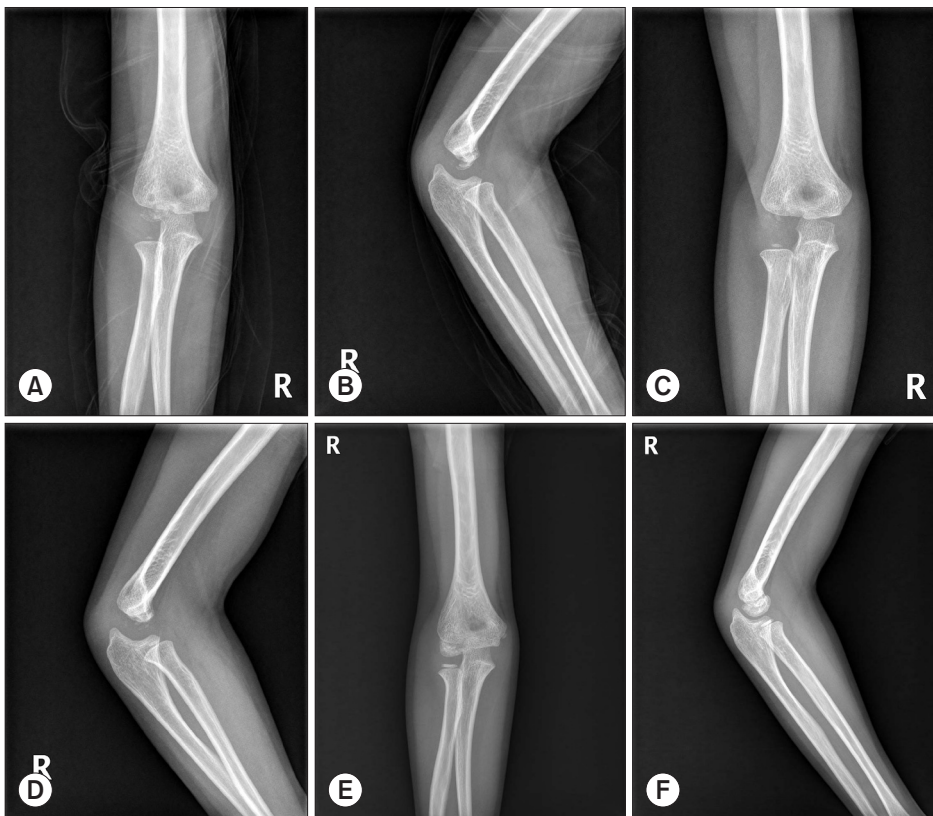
(A, B) At 2 months, follow-up anteroposterior and lateral plain radiographs show demineralization and bone resorption of the capitellum. (C, D) At 5 months follow-up, plain radiographs show more progression of demineralization and bone resorption and disappearance of the capitellum. (E, F) At 31 months follow-up, plain radiographs show the healing process of Panner's disease of the right elbow. The re-ossification of the capitellum is shown. The volume of the re-ossified capitellum is relatively enlarged.
